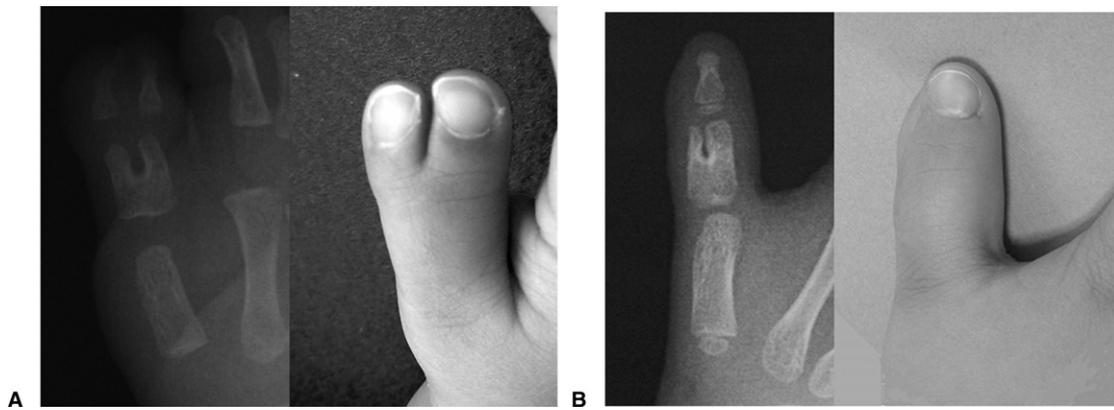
A Preoperative x-ray of Wassel type III polydactyly, in which 2 thumbs were almost equal in size. The width of the distal phalanx was 61% of that of the first metacarpal. B At age 5, the width of the distal phalanx increased to 78%.
